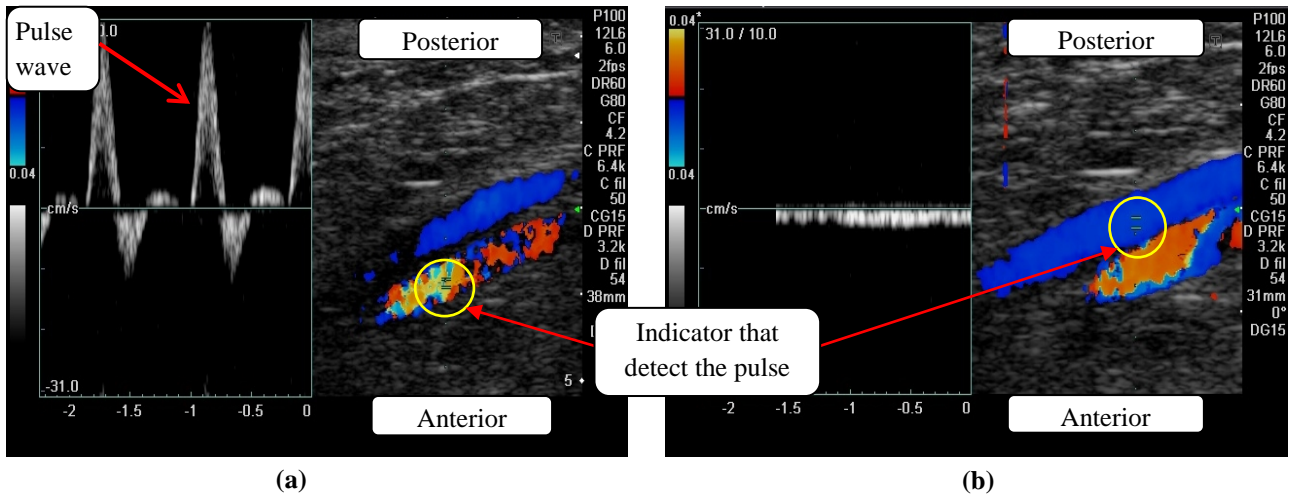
Doppler color image from ultrasound; (a) indicate the popliteal artery, (b) indicate the popliteal vein.
